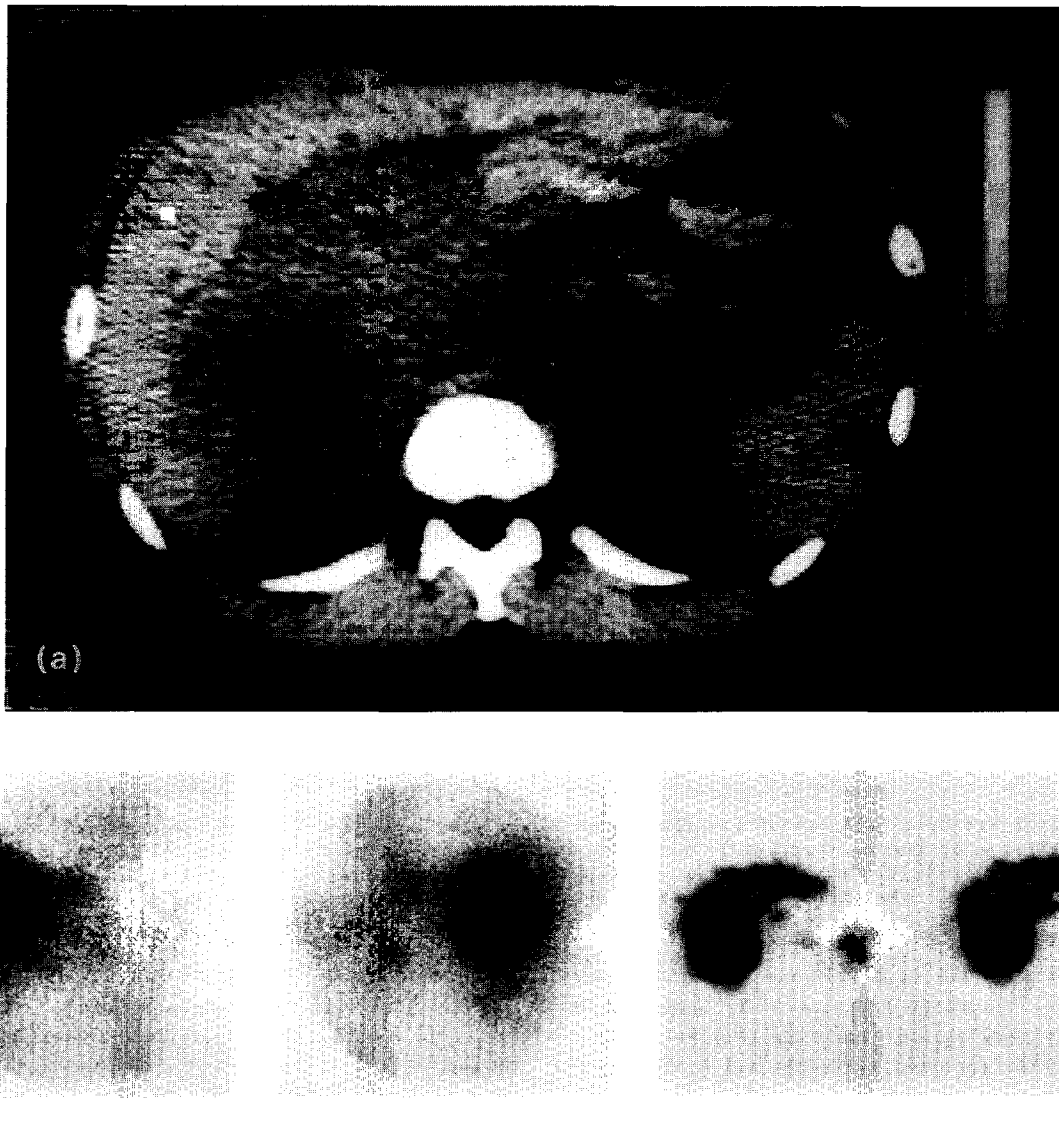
Patient (number 6) with carcinoid syndrome with flushes and diarrhoea also suffered from pain and vomiting due to severe obstruction of the horizontal part of the duodenum as demonstrated in a CT scan (a) and with a barium meal (b). The radionuclide imaging tests (c) were both positive, showing the large tumour mass as a mid-abdominal triangle. Clearly prolonged uptake in both kidneys is shown in the  $^{111}\text{In}$ -pentetreotide scan.
